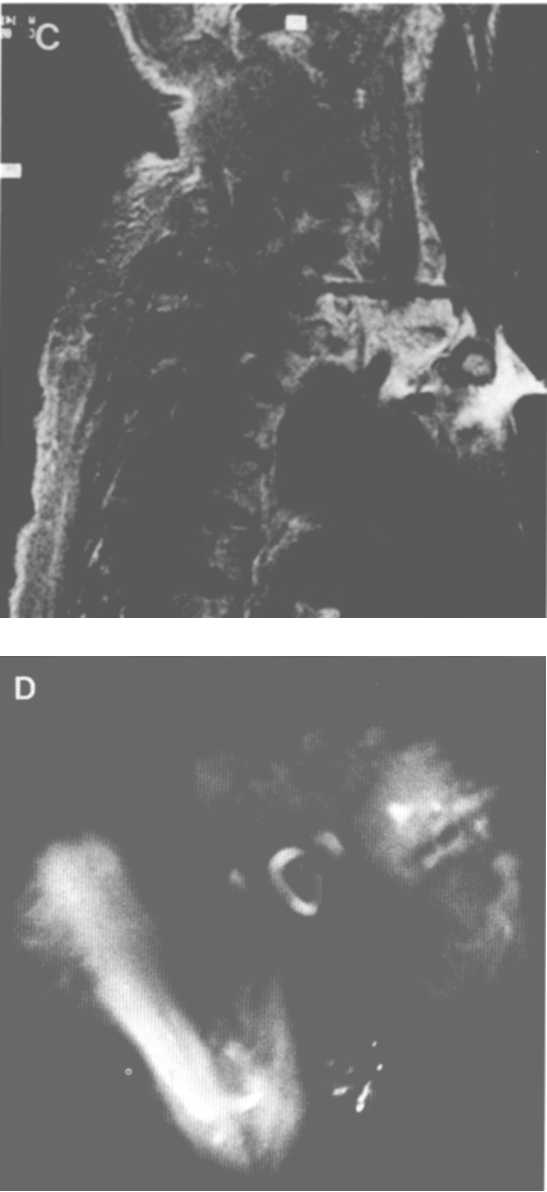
(C) MRI-scopic view (sagittal plane). (D) Endoscopic view of the ganglion stellatum.
